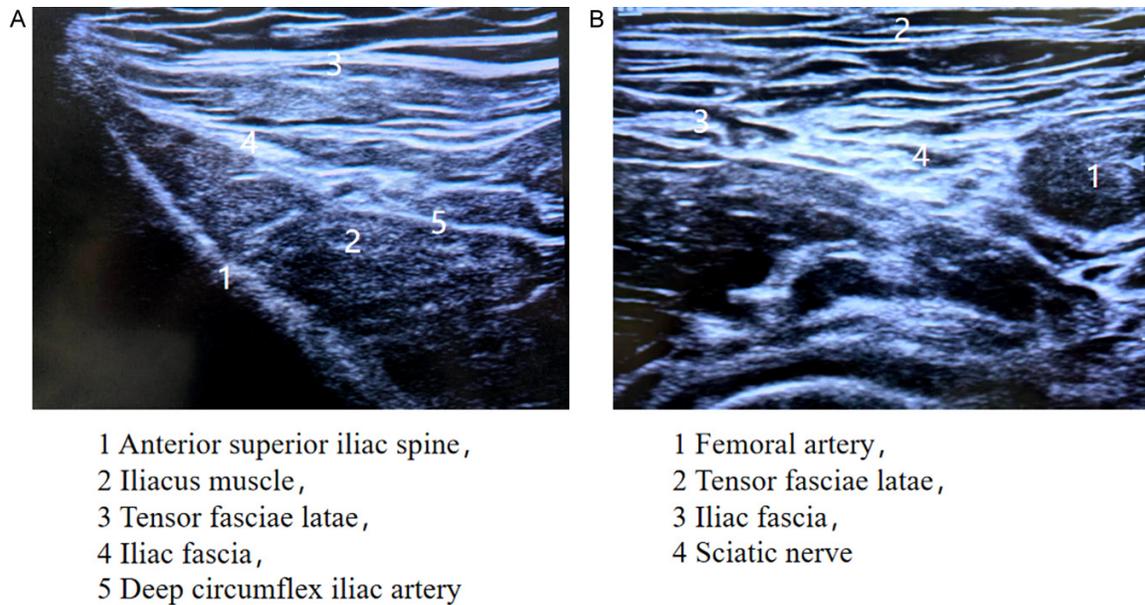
Ultrasound images of relevant anatomic structures for the iliac fascia compartment block. A: Ultrasound anatomic view of the anterior superior iliac spine region, used for initial localization of the block; B: Ultrasound anatomic view adjacent to the femoral artery, assisting in confirmation of vascular and neural structures within the block area.
